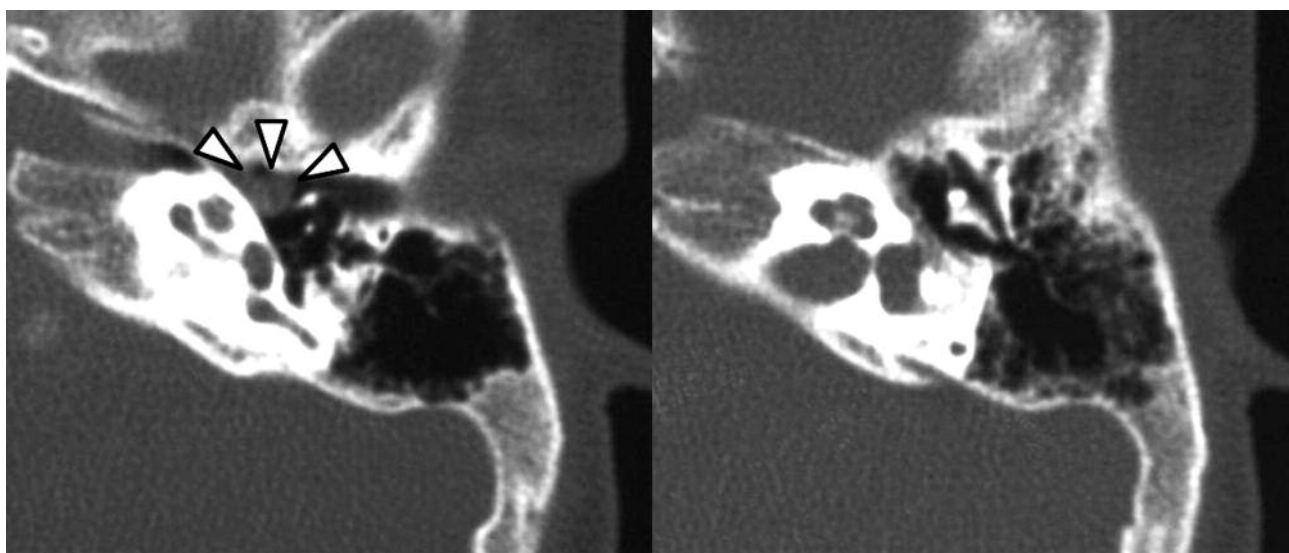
Axial temporal bone computed tomography six months after the trauma demonstrated an isolated soft tissue density in the tympanic cavity (arrow heads). The other soft tissue density in the middle ear cavity disappeared.
